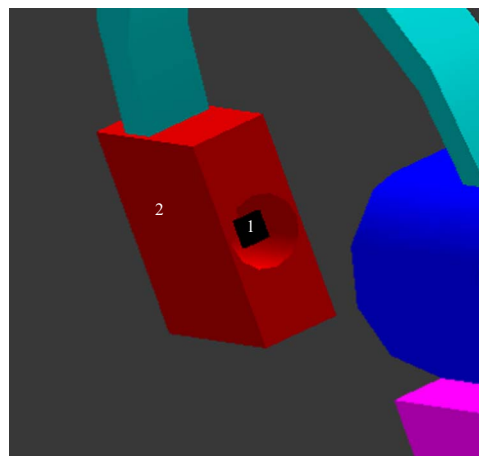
Scheme of the X-Ray tube and the air cell used to calculate KAP. 1 – Air cell, 2 – X-ray tube. For the best view of the figure, the scene was loaded without the bed and without the patient.
